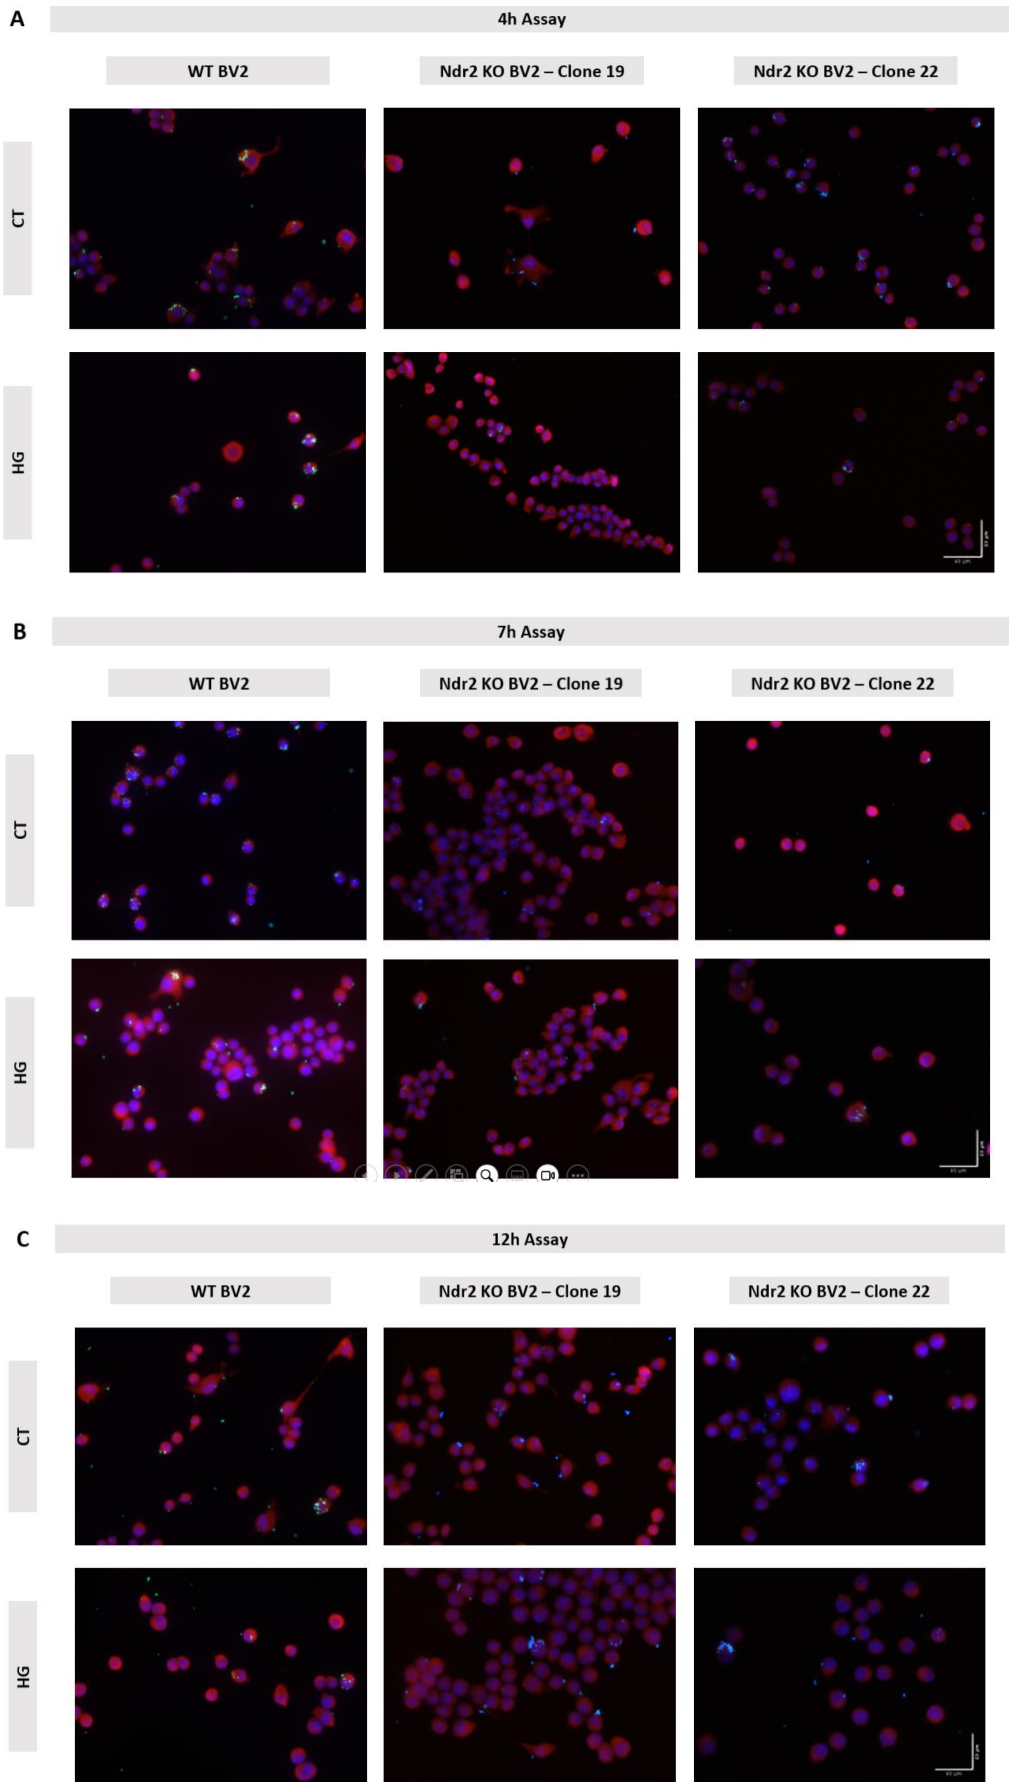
Representative fluorescent images of phagocytic activity. WT BV-2 (WT) and Ndr2 downregulated BV-2 (Clone 19 and Clone 22) cell cultures were incubated in 5.5 mM glucose (CT) or 30.5 mM glucose (HG) for different
